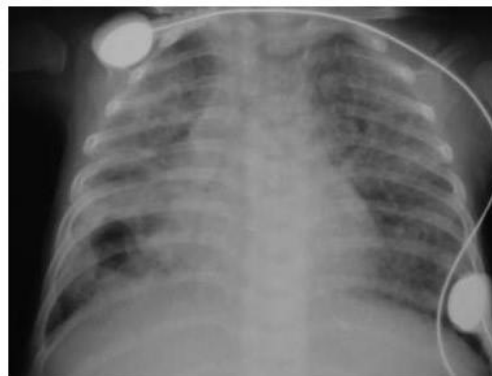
Chest radiograph. Extensive confluent air-space disease is present involving most of the right lung with some lower zone breakdown. The left lung also demonstrates extensive, but patchy air-space disease. The bronchus intermedius is narrowed and the left main bronchus is not well demonstrated.
